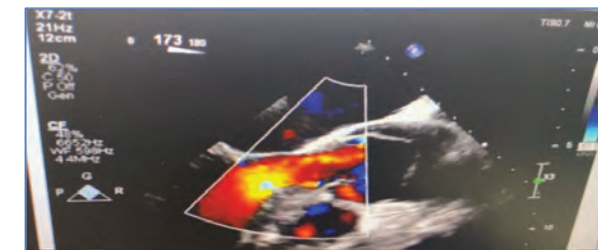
Echo image; showing Aortic root dissection flap with severe AI on color Doppler.
